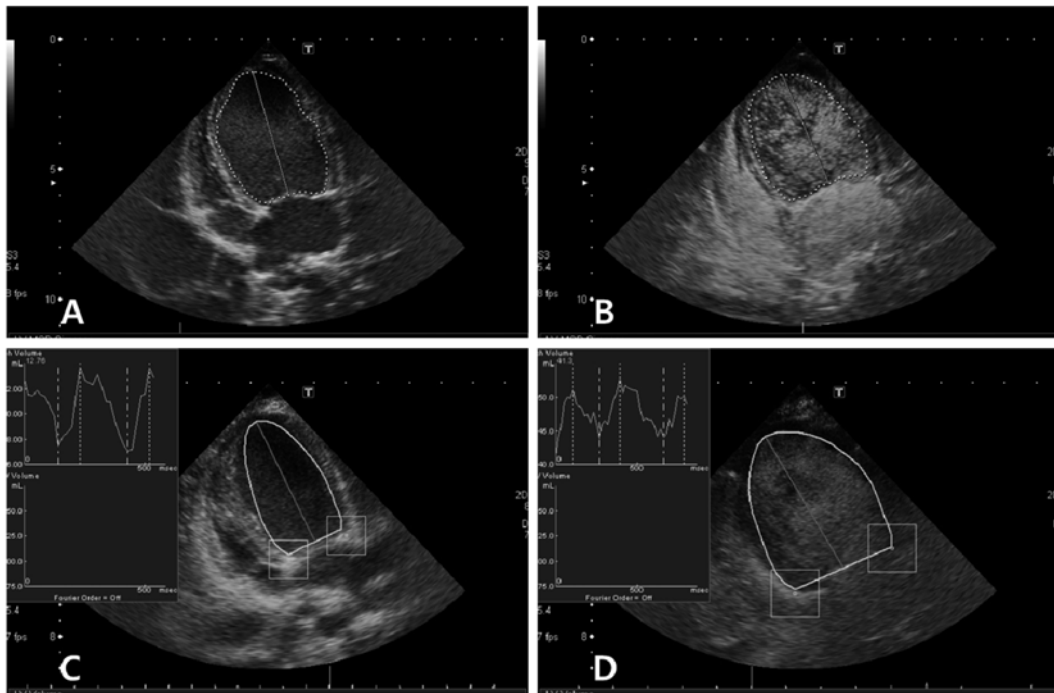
Pre-contrast and post-contrast echocardiographic images of left ventricle by the modified Simpson’s method and automated contour tracking (ACT) method. (A) Pre-contrast images by the modified Simpson’s method. (B) Post-contrast images by the modified Simpson’s method. (C) Pre-contrast images by the ACT method. (D) Post-contrast images by the ACT method.
